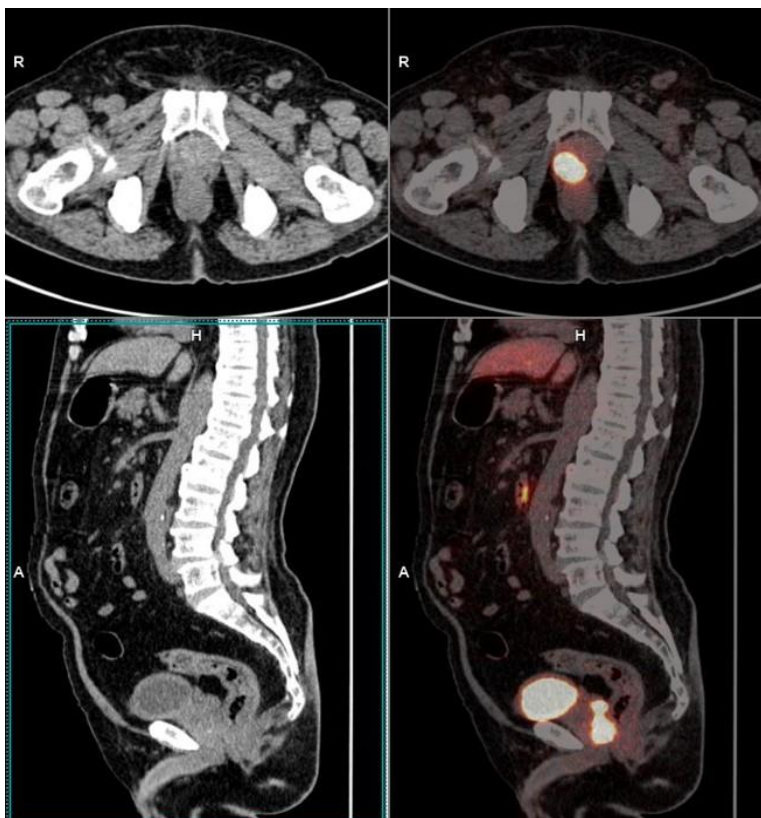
PSMA PET-CT showing the presence of malignant mass in the prostate with intense PSMA uptake and non-avid mass in the rectum.
